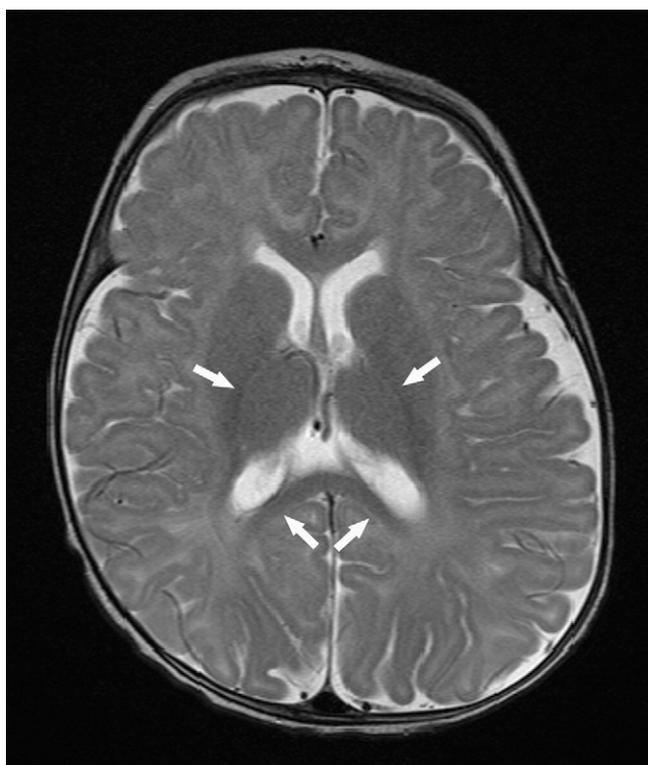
Axial T2-weighted image of brain at 8 months of age demonstrates myelination of the splenium of corpus callosum and posterior limbs of internal capsules (arrows). (Image courtesy of Deborah Zarnow, MD.)
